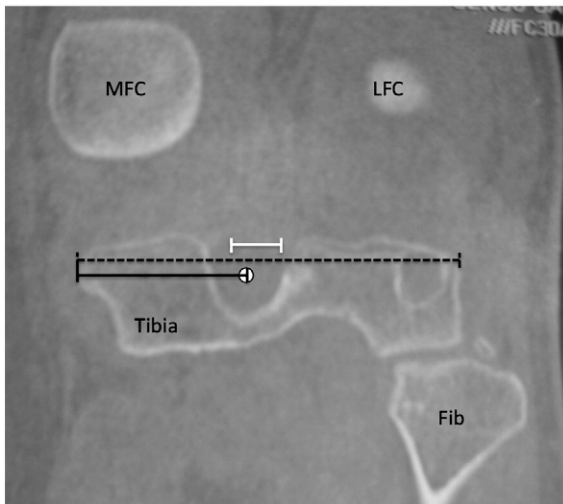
A coronal plane computed tomography image of a left knee following arthroscopic posterior cruciate ligament (PCL) reconstruction. The centre of the entry point of the PCL tibial tunnel into the joint is noted with a white dot. The distance from the centre of the tunnel to the medial border of the tibial plateau was measured (solid black line), as was the total width of the tibial plateau in this plane (dashed black line). The white line denotes the expected medial–lateral position: placement of the tunnel within 5 mm of a point 48% of the way across the plateau from the medial border. The medial (MFC) and lateral (LFC) femoral condyles, tibia, and fibula (Fib) are labeled.
